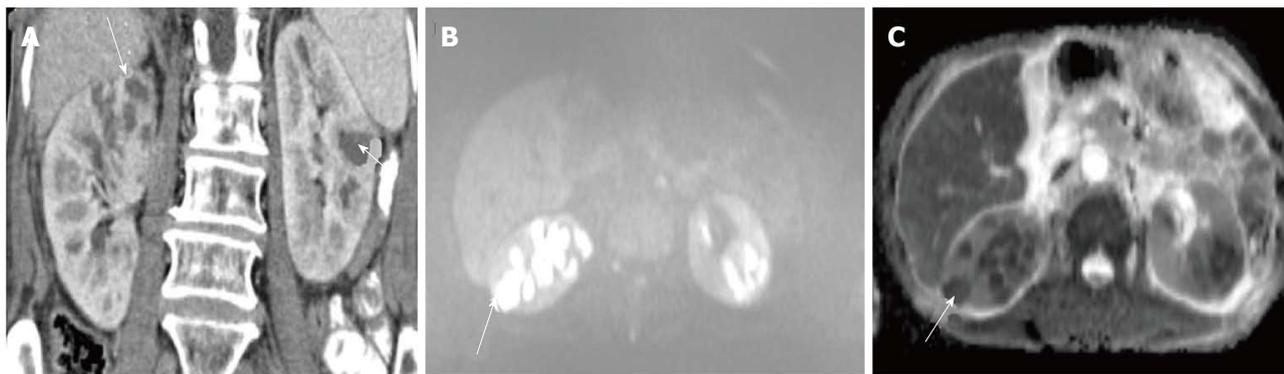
Diffusion weighted magnetic resonance imaging. A: CECT of a diabetic middle aged male shows multiple peripherally enhancing lesions in bilateral kidneys (arrows). B, C: DW-MRI (b = 1000) (B) and corresponding ADC maps (C) show that the lesions have restricted diffusion. Aspiration revealed the pyogenic nature of the abscess. There was excellent response to antibiotics. CECT: Contrast-enhanced computed tomography; DW-MRI: Diffusion weighted magnetic resonance imaging.
